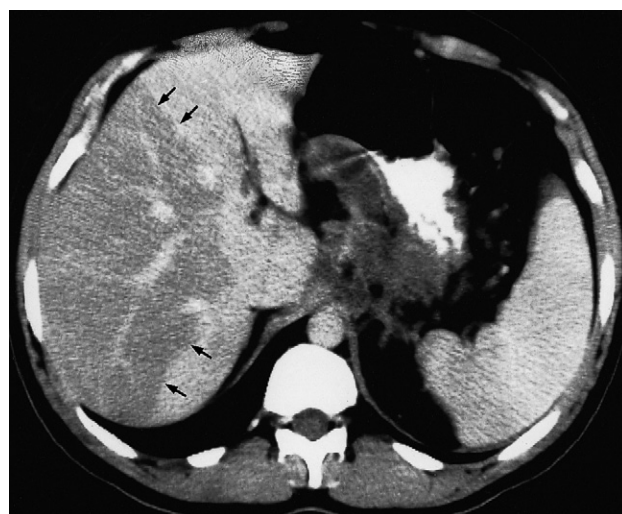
Fatty degeneration of the liver shown by CT as a large focal area of reduced attenuation in the right lobe of the liver (arrows).
